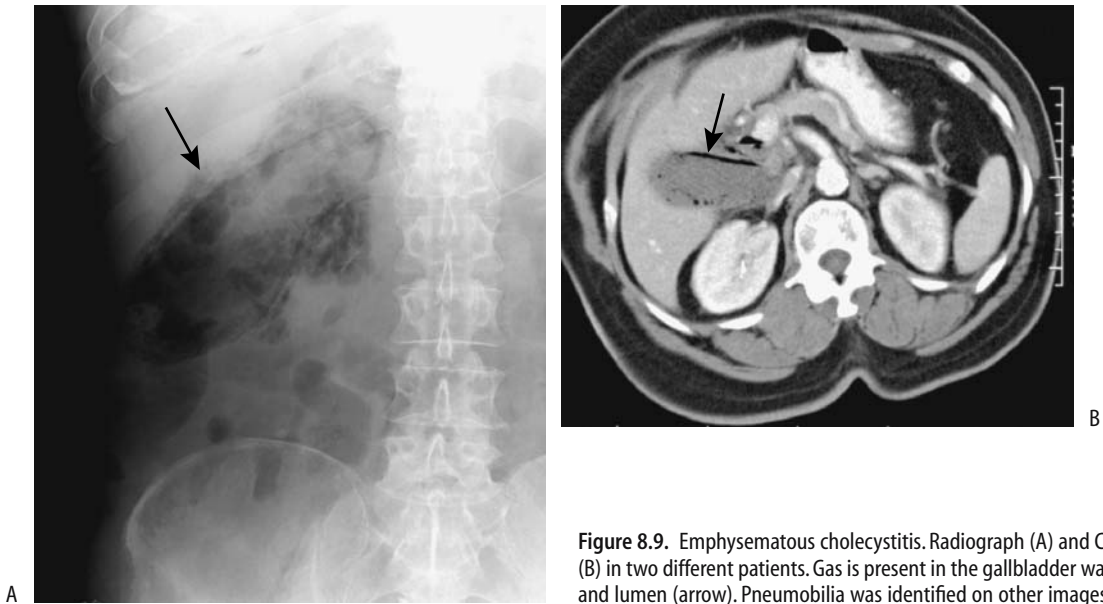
Emphysematous cholecystitis. Radiograph (A) and CT (B) in two different patients. Gas is present in the gallbladder wall and lumen (arrow). Pneumobilia was identified on other images.
